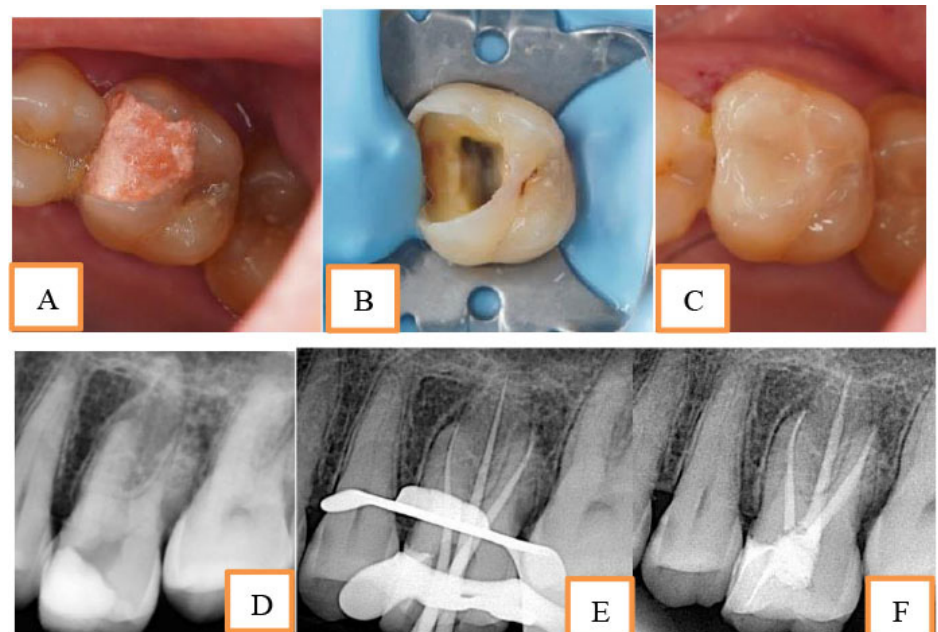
A. Preoperative condition, B. Removing caries, C. Final restoration, D. Preoperative radiograph, E. Trial master gutta percha radiograph, F. Final obturation radiograph.
